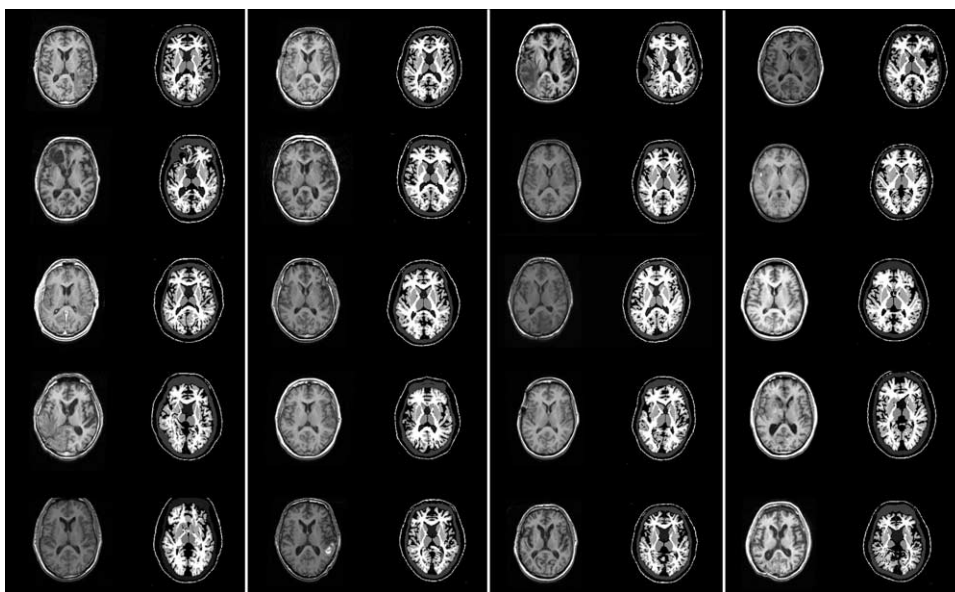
Results of the automatic delineation (AD) for a set of 20 patients' magnetic resonance images made during the calibration of the AD with the same parameters set for the 20 patients.
